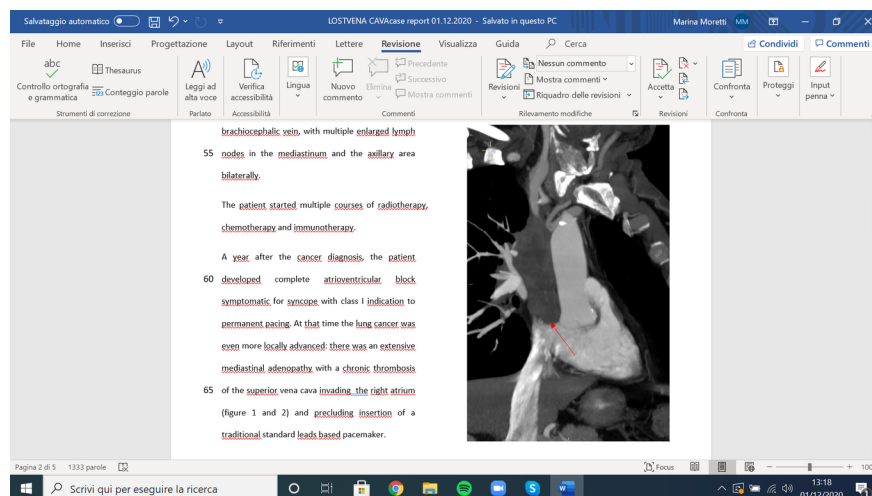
CT Multiplanar Reconstruction (MPR) of the heart, focusing on thrombosis of the superior vena cava invading the right atrium (red arrow)
